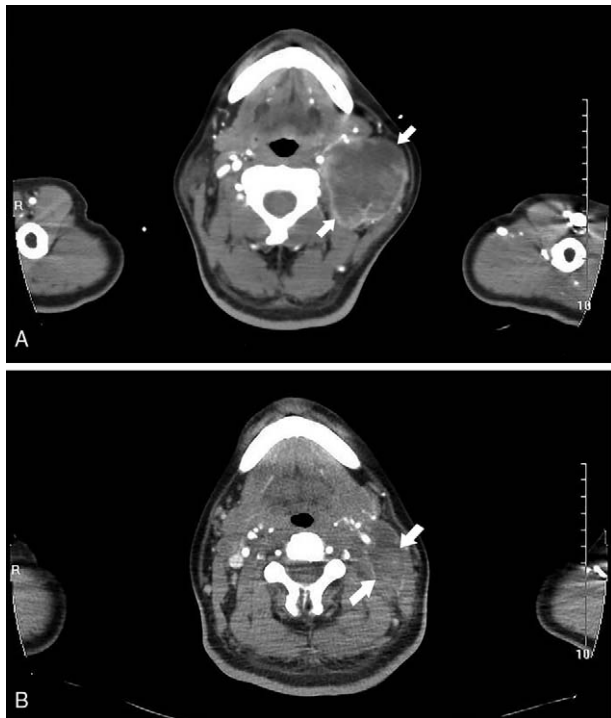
CT scans showing the lymph node shrinkage on the (A) left side before and (B) after chemotherapy. CT=computed tomography.
